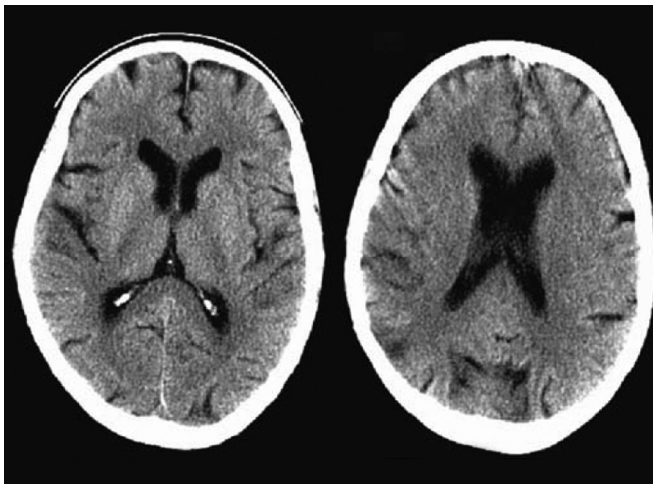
Noncontrast CT within 2 hours of stroke showing ill-defined hypodensity in the right parietotemporal region
